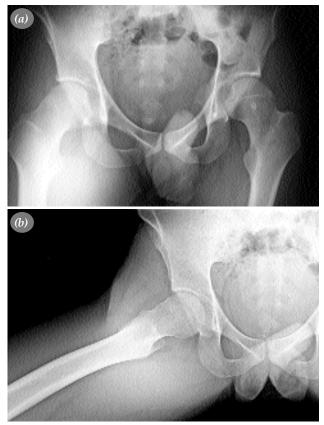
(a) The right hip radiograph did not reveal any pathology apart from a soft tissue radio-opacity due to the flexion contracture of the hip. (b) Lateral radiographs of the right hip.
